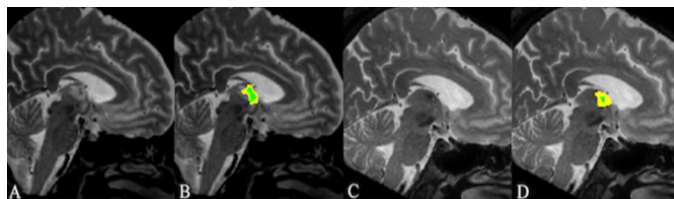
Sagittal image showing the ATN lesion (1 day post FUSA) on T2-weighted imaging (A), and the clusters with significant RDI change between baseline and 24 hours imaging (B; clusters based on percentage RDI increase from baseline – green: 61.7% increase and yellow: 30.6%). The insets C&D are show the 3 months imaging results for T2-weighted and RDI analysis respectively (percentage RDI increase from baseline – green: 17%, yellow: 7%).
